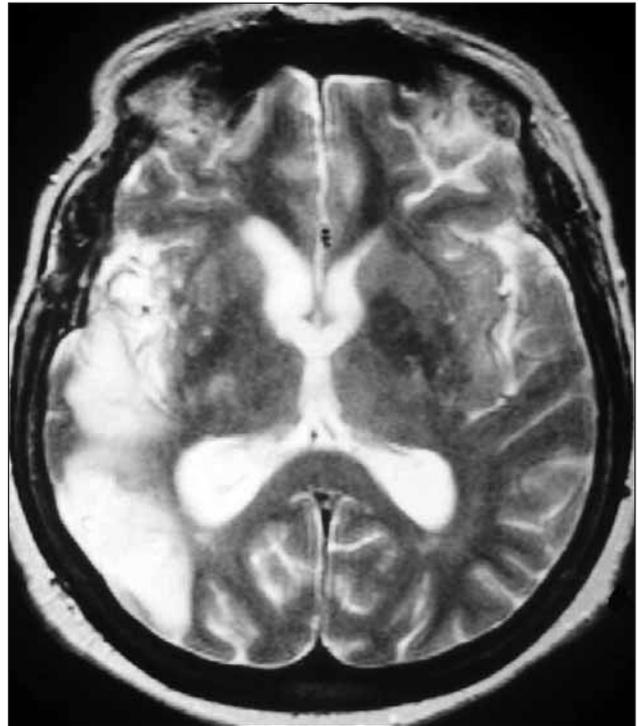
An MRI taken three-months after the insult showing the ischemic area including right temporal and parietal lobes and right insula.
